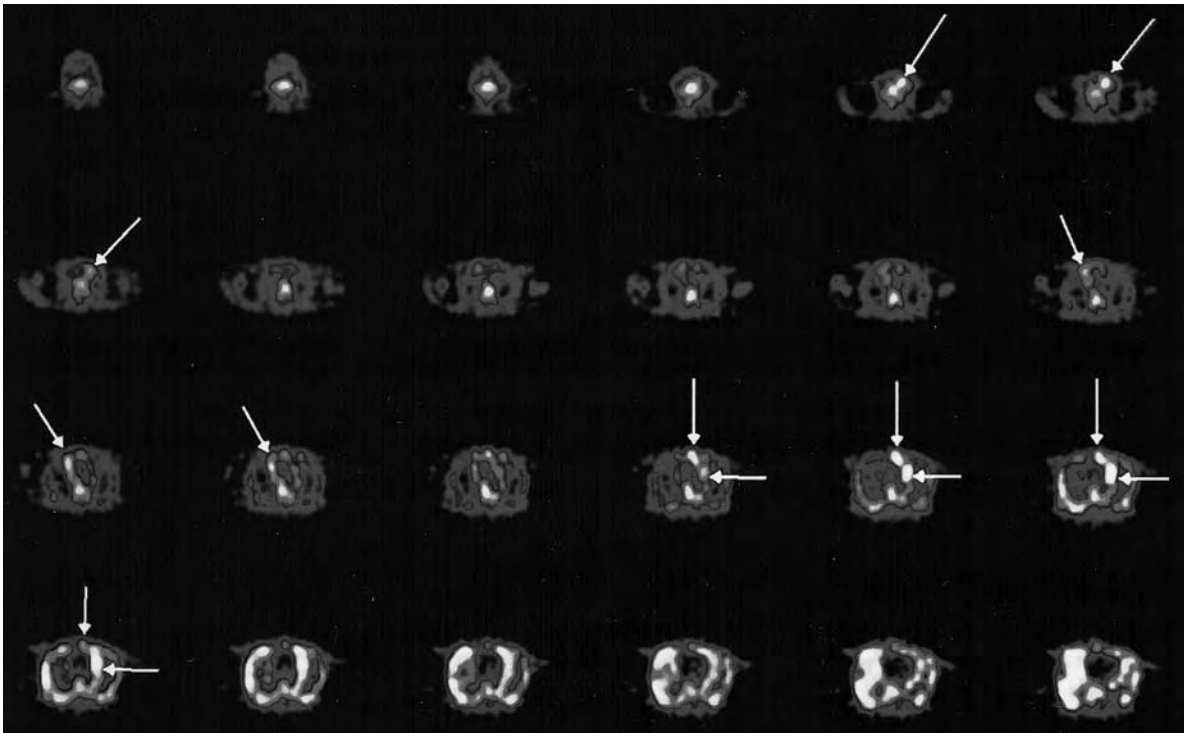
^{111}In -DOTA-lanreotide scintigraphy in a patient with Hürthle cell carcinoma and an ^{131}I -negative whole-body scan visualizes several tumor sites (arrows). Transverse images indicate major tumor lesions in the left neck, mediastinum, and right basal lungs
